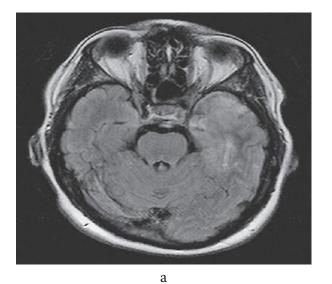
Brain MRI: edema temporobasally on the left (a), with eradicated border between the gray and white matter (b).
